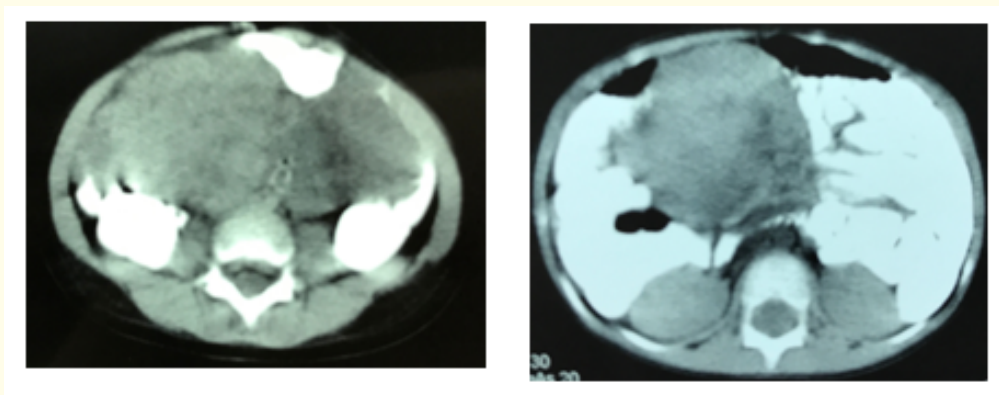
CT of the abdomen and pelvis. Extensive formation expansive density of soft parts, solid, heterogeneous, little contours defined, in abdominal cavity and retroperitoneal, 13 X 8 X 9 Cm.
